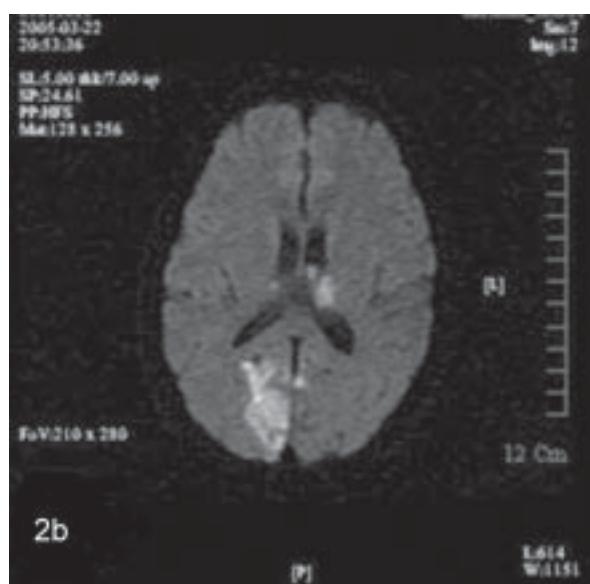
Brain MRI showing multiple new infarcts in the cerebellum, occipital lobe (a) and left thalamus (b) on the fifth day of admission.
